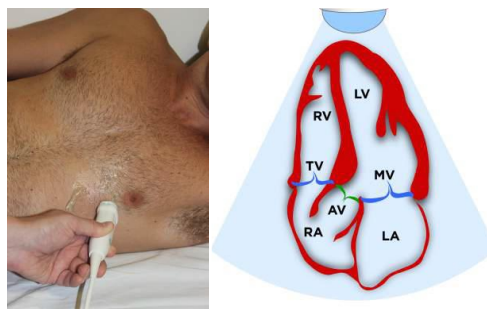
Imaging technique in the apical five chamber view and anatomic sketch
